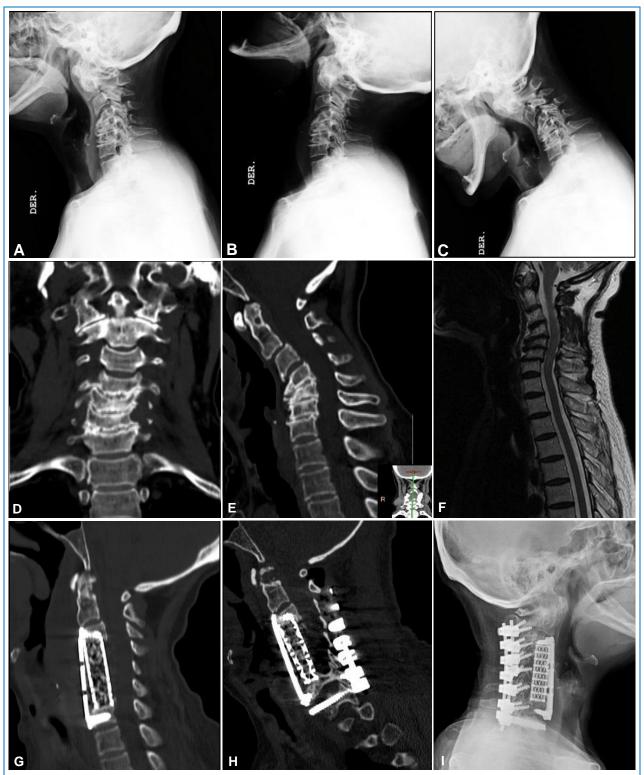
(Case 4): 60-year-old female patient with rheumatoid arthritis for 30 years, under treatment with prednisone, Etanercept and methotrexate. History of high blood pressure, chronic gastritis, wrist arthrodesis, elbow dislocation surgeries and appendicitis. Neck pain was the main symptom, being classified on the Ranawat scale as type II. Inflammatory serum markers: CRP 11 and ESR 38. X-ray images show involvement of the subaxial cervical spine with signs of instability on dynamic images in (A) neutral position, (B) hyperextension and (C) hyperflexion. (D, E) Tomography images and (F) Cervical MRI that more clearly show the bone and soft tissue involvement at the cervical spinal level. The patient underwent surgery on two occasions, (G) initially an anterior arthrodesis was performed by performing a corpectomy with placement of a cylindrical titanium mesh and anterior plate. (H, I) In a second stage, a posterior arthrodesis was performed with screws to lateral masses.
